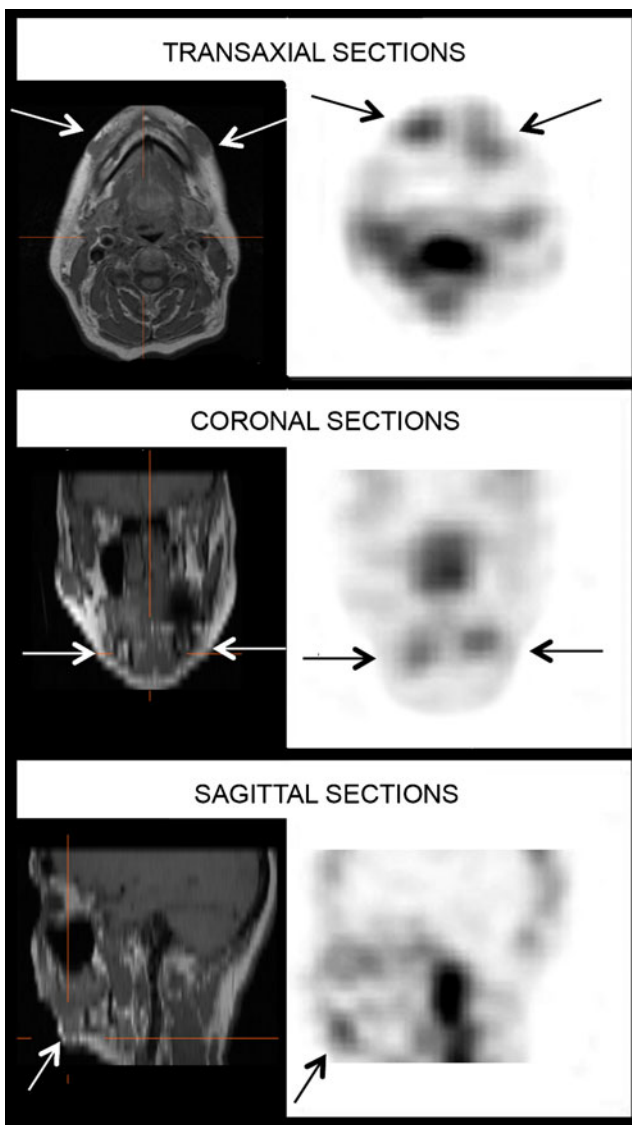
Transaxial, coronal and sagittal MRI (fat-suppressed) and SPECT images in patient 9 (MR) 3 h after WBC injection. The filler is easily detectable in the MRI images and shows positivity in the WBC scintigraphy images (*arrows*)
